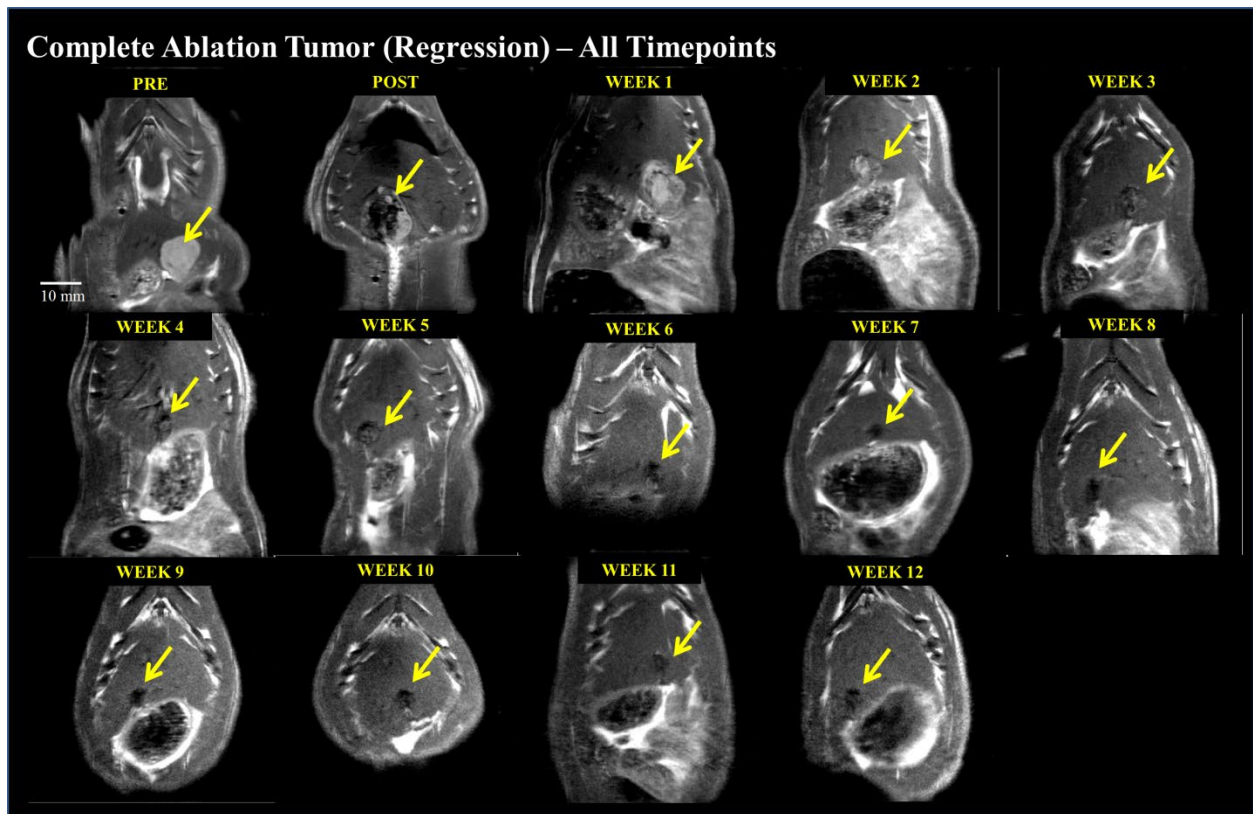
T2W MRI appearance of histotripsy treated tumor (complete ablation) at all timepoints. Complete ablation - pre-treatment (mildly hyperintense), post treatment ablation zone (hypointense), ablation zone at weeks 1-2 (mildly hyperintense), weeks 3-6 (mildly hypointense, size regression), weeks 7-12 (hypointense, size regression) with <5 mm hypointense region observed at final imaging timepoint. This figure demonstrates all imaging timepoints for the case demonstrated in Figure 4-4A.
